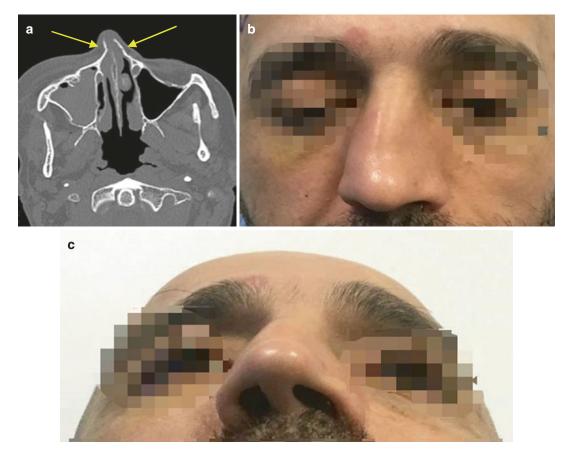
Bone windowed axial CT image (a) and clinical photography images (b, c) of a nasal fracture with rightsided nasal bone deviation
